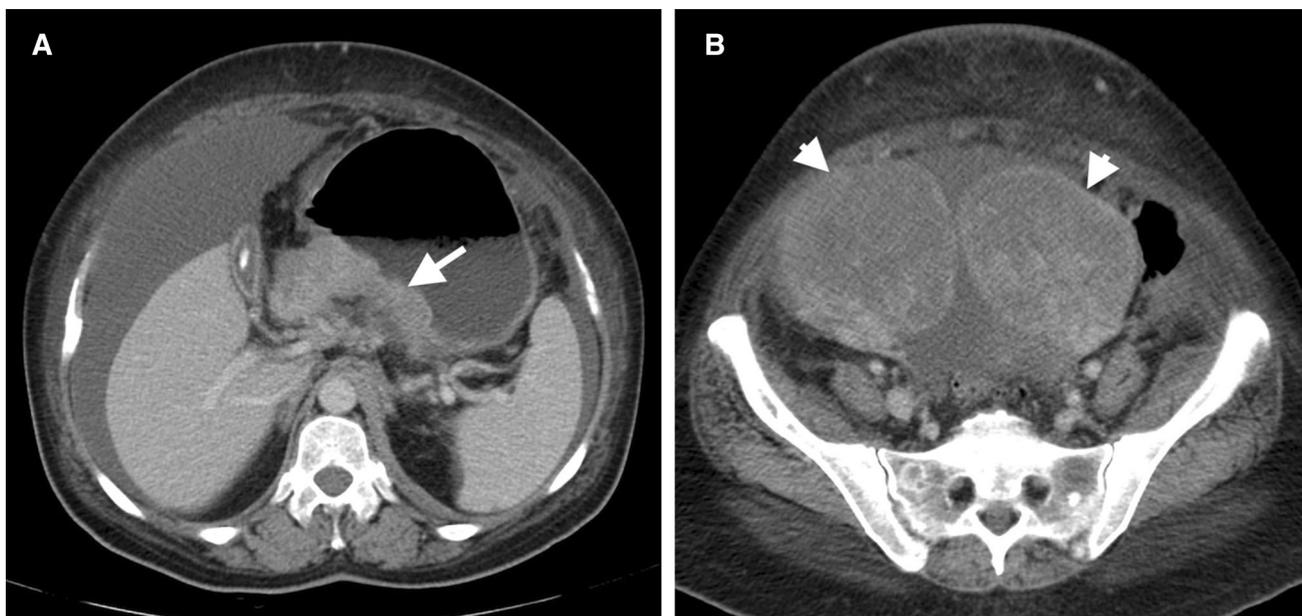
Forty-one-year-old woman with newly diagnosed gastric signet ring cell carcinoma. CT scan was performed for staging purposes before treatment planning. A Axial contrast CT image demonstrates diffuse wall thickening in the lesser curvature of the stomach (arrow). B Large complex
